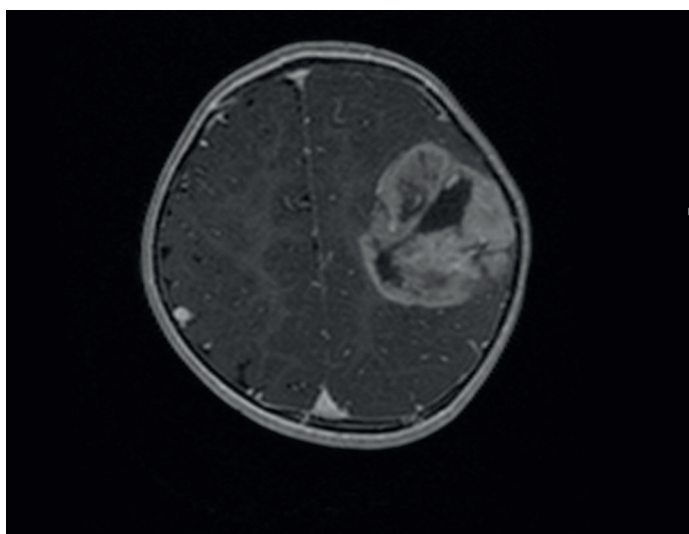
Axial postcontrast T1-weighted image
